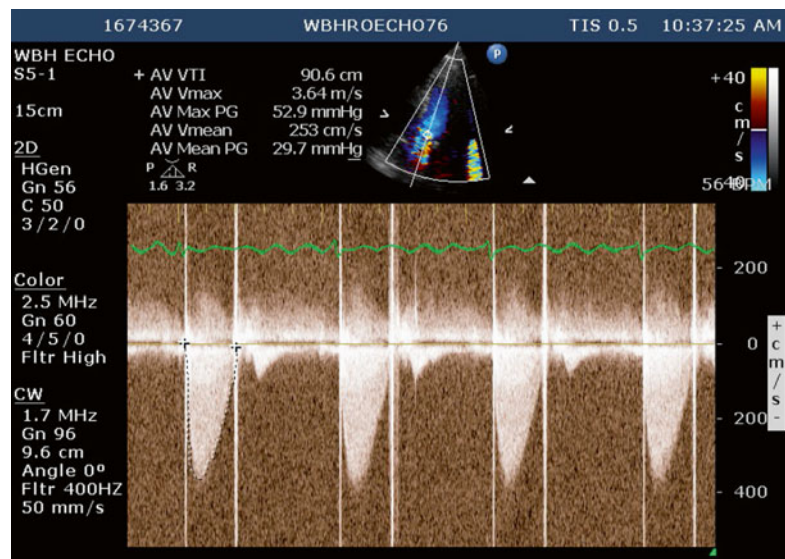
CW Doppler imaging across the mechanical aortic valve. The CW jet contour is triangular and early peaking (AT < 100 ms), consistent with the absence of prosthetic valve stenosis as what may occur with VP-PM. Other causes of increased trans-valve gradient in the absence of stenosis include high flow states, pressure recovery, or any combination of the above
